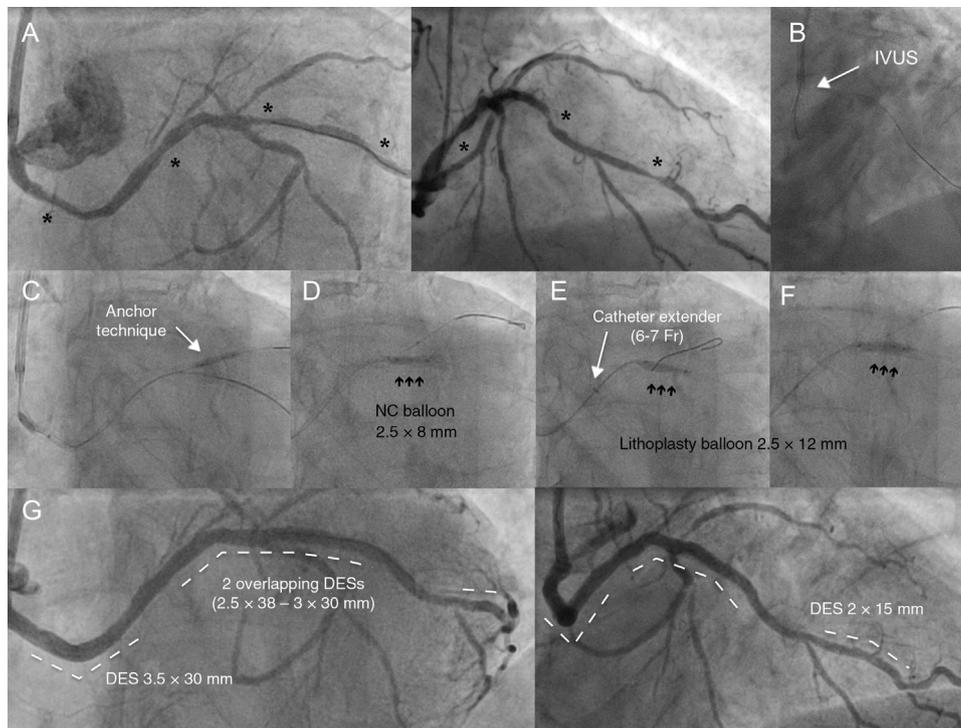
A: Calcified, tortuous circumflex artery with distal, medial, and proximal lesions (asterisks). B: The intravascular ultrasound (IVUS) catheter could not be advanced. C: Application of the side-branch anchor technique did not allow advancement of the lithoplasty balloon. D: Underexpansion of the 2.5-mm noncompliant (NC) balloon in the medial area helped advance the catheter extender and move the lithoplasty balloon forward (E). E: Unsuccessful dilation with 40 pulses. F: Opening of lesion after 60 pulses. G: Outcome after placement of 4 drug-eluting stents (DES).
